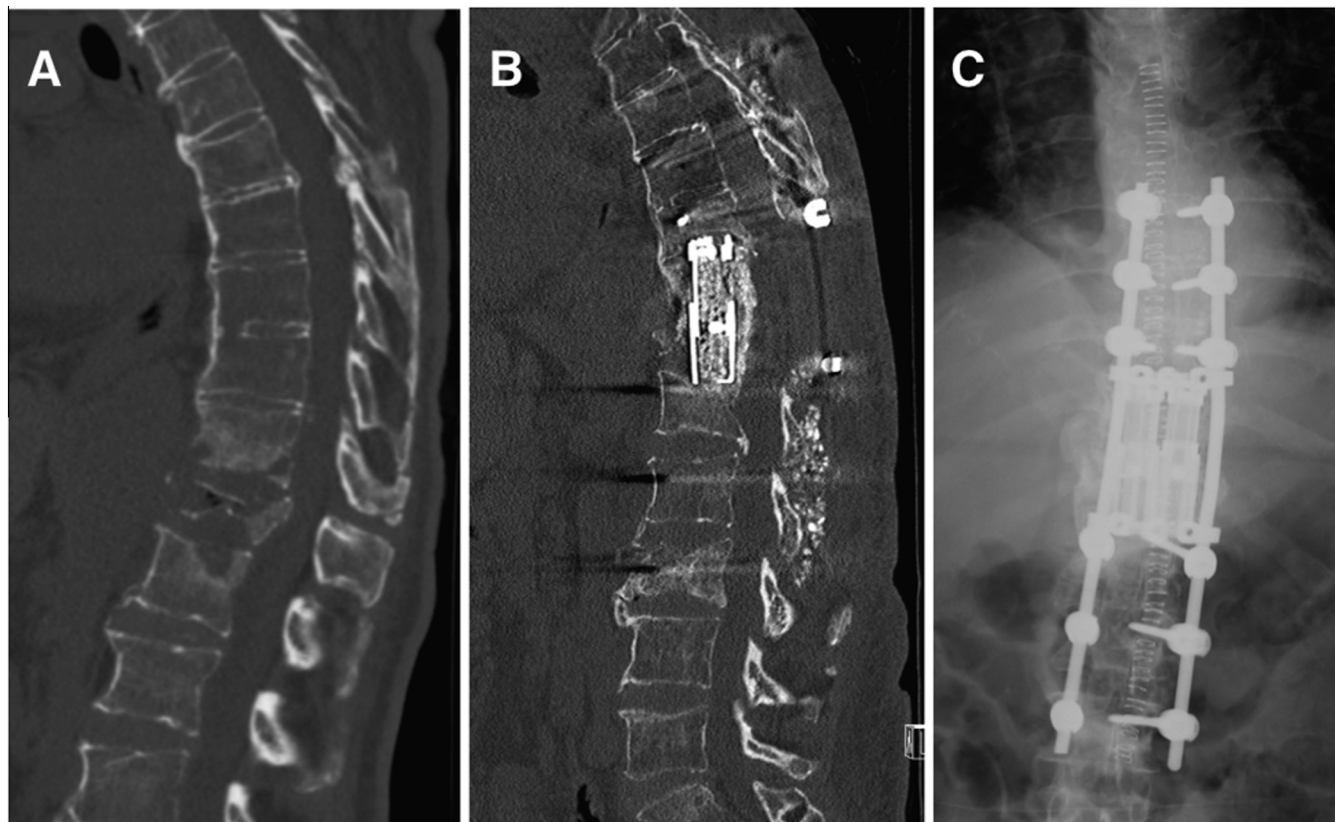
(A) Midsagittal CT scan of a patient with T11–T12 pyogenic vertebral osteomyelitis both pre-operatively and (B) post-operatively. Expandable cages have been inserted after corpectomy and bone substitute packed. The spine is stabilised with pedicle screws from T8–10 and L1–3 joined by rods. (C) A post-operative anteroposterior radiograph confirming the position of the cages and screw-rod construct.
